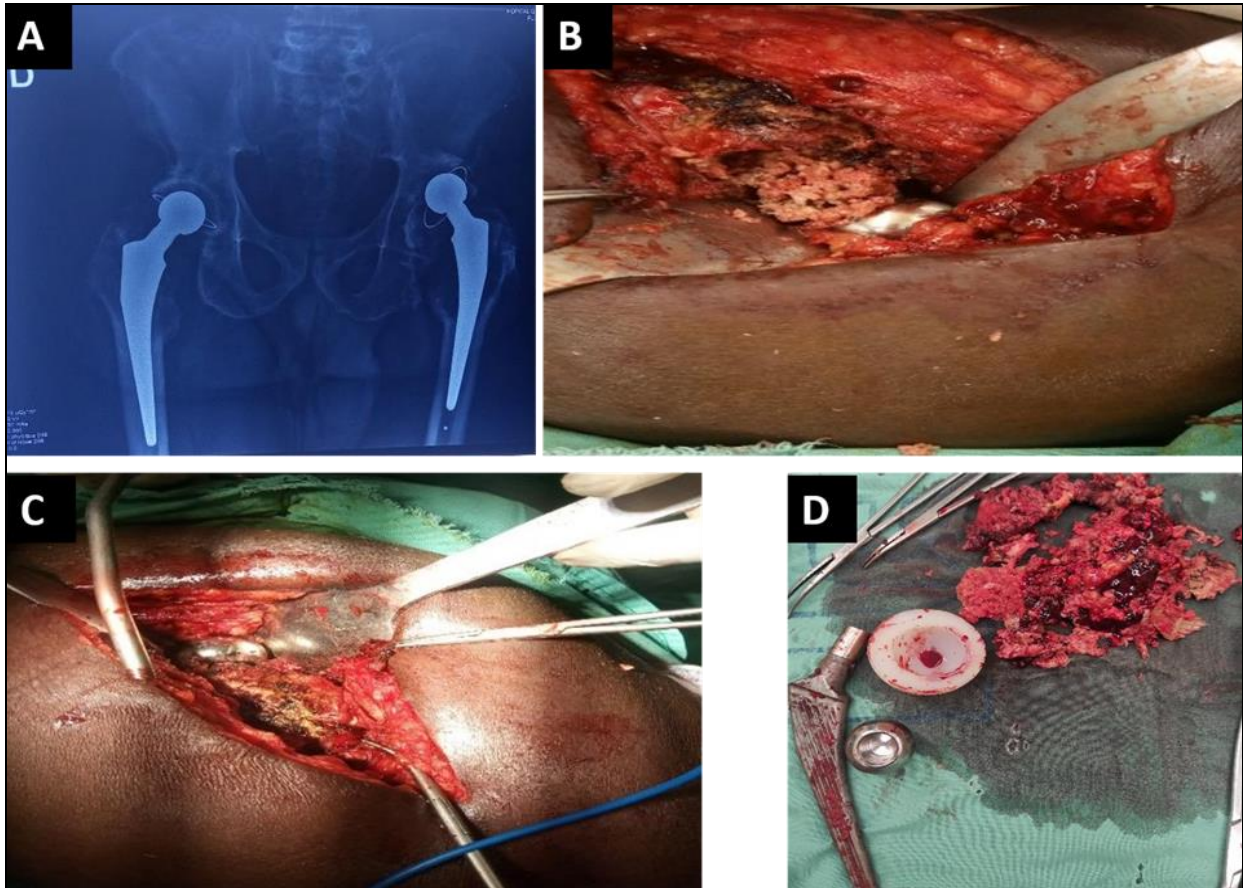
Septic loosening of a hybrid reverse THA. A, anteroposterior radiographs. B, C, D: peroperative image during revision (Girdlestone)
